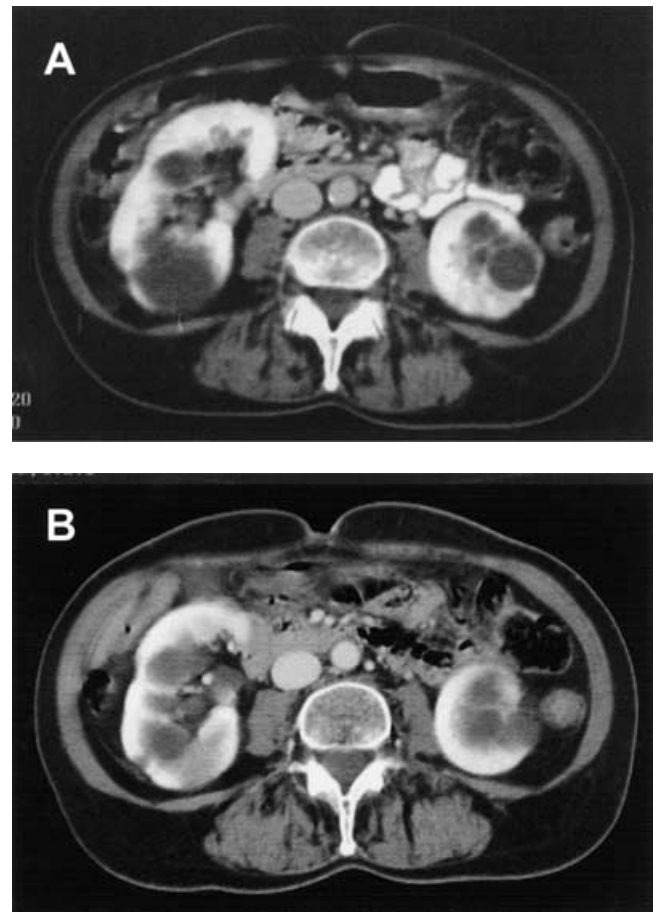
Representative images of abdominal computed tomography (CT) scans of a patient with autosomal-dominant polycystic kidney disease (ADPKD), before (A) and after 2-year treatment (B) with the somatostatin analogue octreotide for an adenoma of the pituitary gland.
